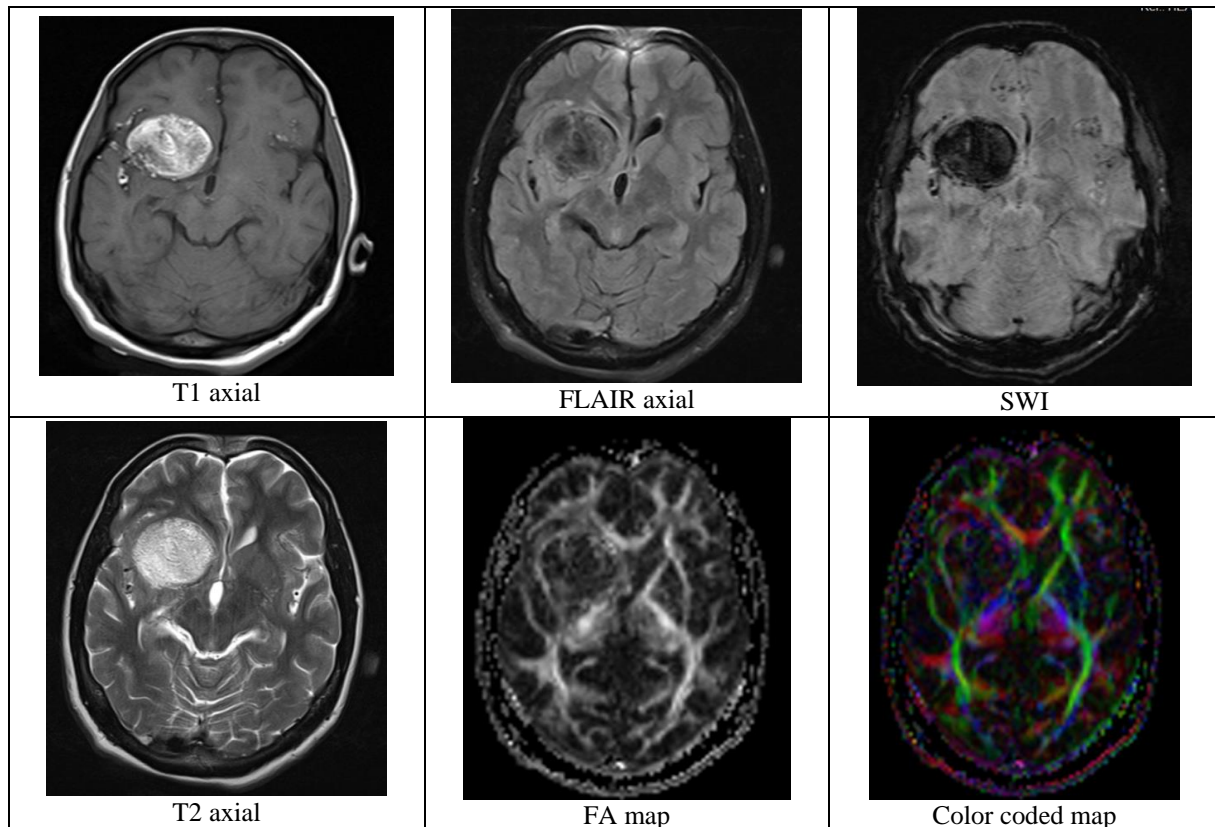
A twenty four year old female patient presented with 1 episode of seizure. MRI shows T1/T2 hyperintense lesion, hypointense in FLAIR in right frontal region. The lesion is blooming on SWI sequence. Multiple sulcal space T1 hyperintensity, c/w ruptured dermoid cyst. DTI shows displacement of right internal, external capsule and corticospinal tract.
